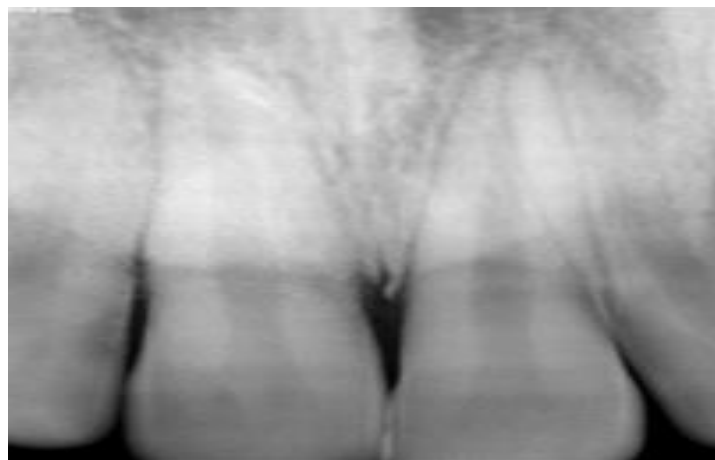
6 months post operative radiograph showing bone healing
